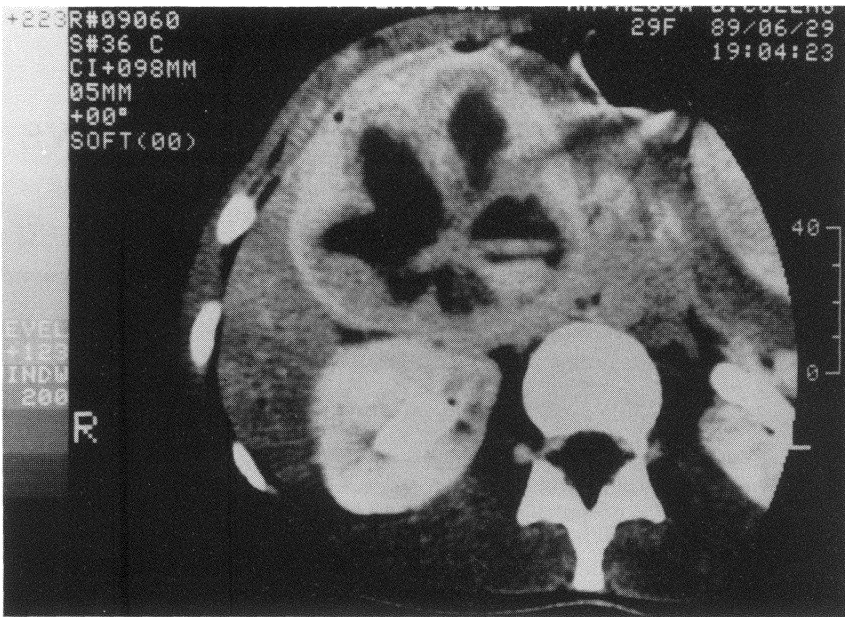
A mass in the head of pancreas on CT scan.
